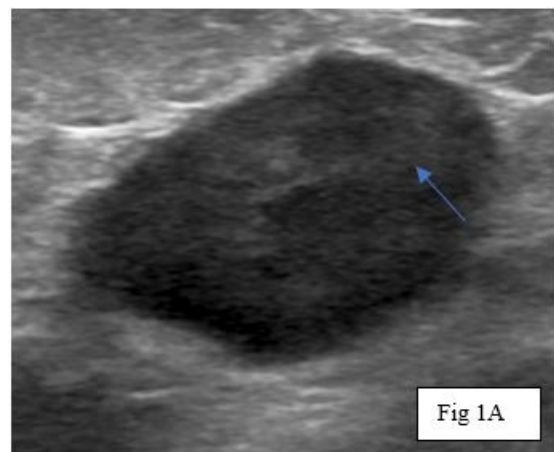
(a): Left breast ultrasound demonstrating an oval hypoechoic mass (arrow) with circumscribed lobulated margins and posterior acoustic enhancement.
